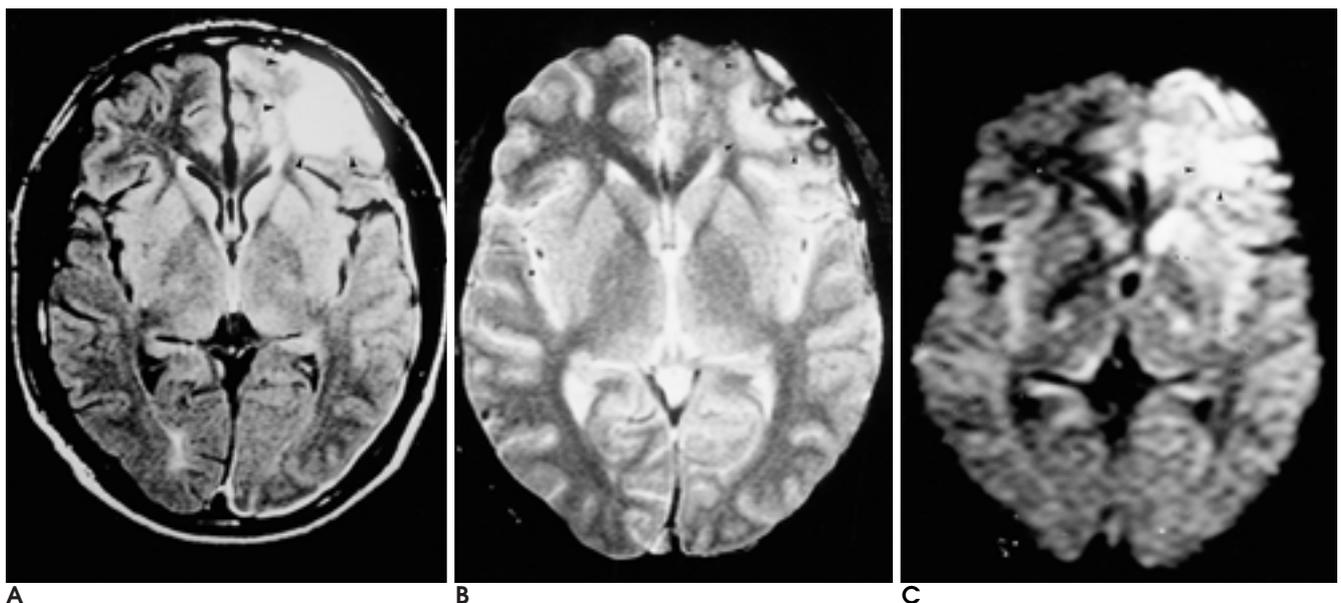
Brain cortical contusion and subdural hemorrhage in 40-year-old man. FLAIR(A), T2 FFE(B) and diffusion weighted(C) images show left frontal high signal intensity due to brain contusion. FLAIR images shows the left frontal lesion more conspicuously than other pulse sequence images. Lt. subdural hematoma only detected on FLAIR images
